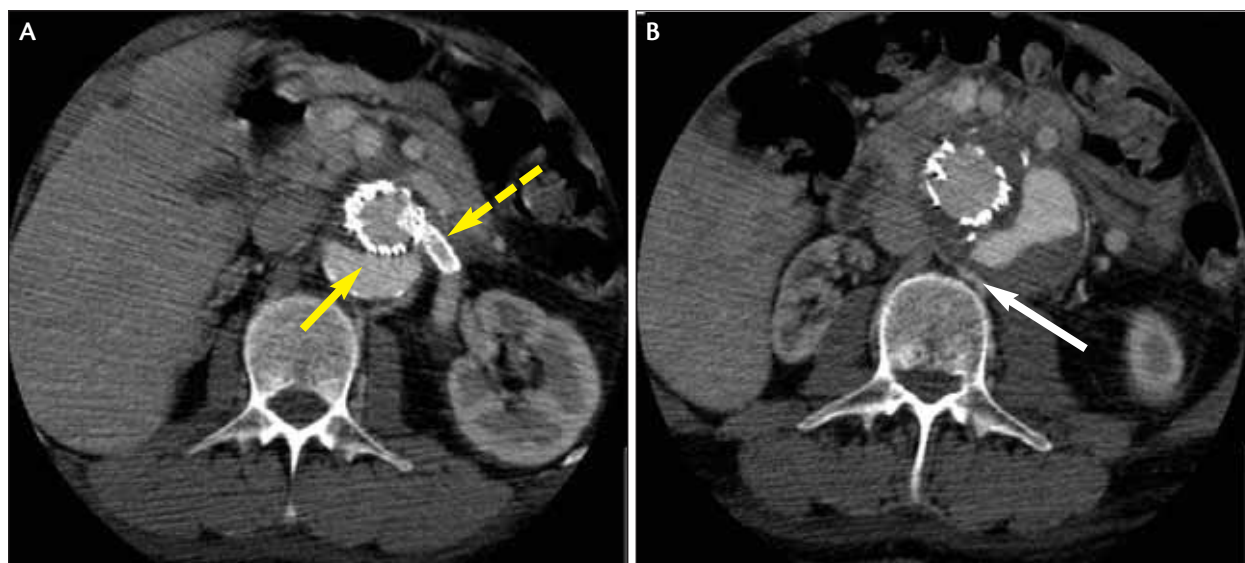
Postprocedure CT shows the renal fenestrated graft *in situ* (dashed yellow arrow) and persistent perfusion of the false lumen (solid yellow arrow) (A). False lumen filling is seen to be via lumbar vessels (white arrow), making this a type II leak (B).
